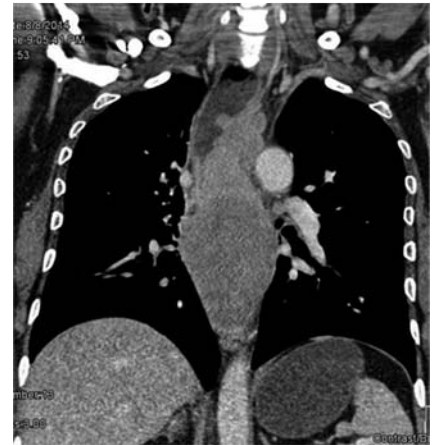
Computed tomography (CT) image showing the extent of the tumor along the whole length of the esophagus with loss of planes to the posterior trachea and aorta.
